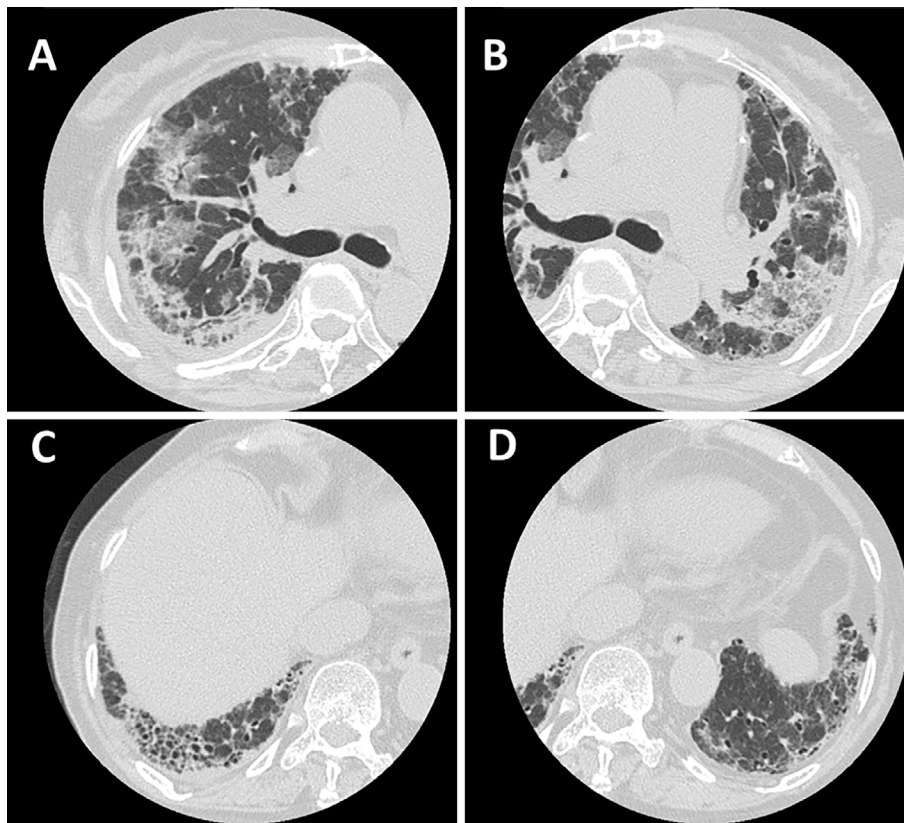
Computed tomography of the chest showing ground-glass opacities and consolidations in both lungs (A, B), in addition to reticular opacities, honeycombing, and traction bronchiectasis in both lower lobes (C, D), which suggest pre-existing interstitial pneumonia (usual interstitial pneumonia pattern) associated with rheumatoid arthritis. Note that both ground-glass opacities and consolidations are absent in both basal lung areas.
